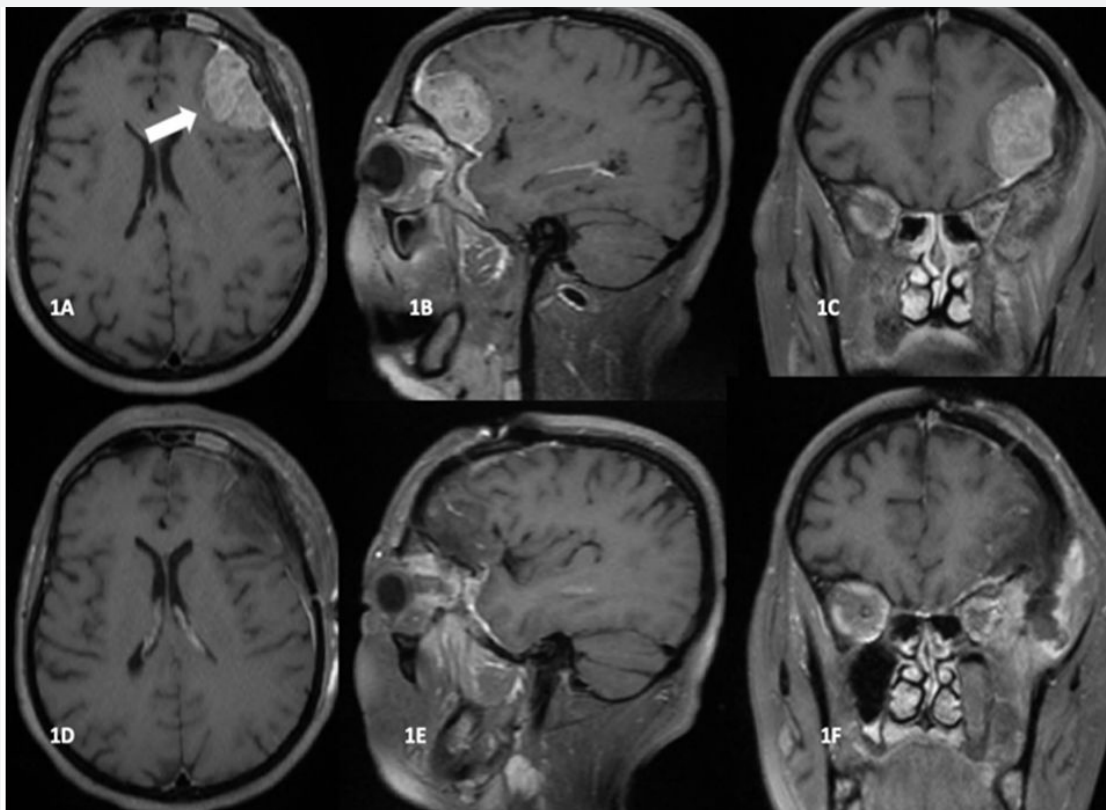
MRI; 1A: In contrast-enhanced T1-weighted sequence axial image, lesion consistent with meningioma with left frontal heterogeneous contrast enhancement (white arrow); 1B: T1-weighted sequence sagittal section shows that the mass is seated on the orbital roof. 1C: T1-weighted sequence, coronal section. 1D: In T1-weighted sequence axial image, it is understood that the mass is totally excised. 1E: T1-weighted sequence, sagittal section image of the same case. 1F: T1-weighted sequence, coronal section
